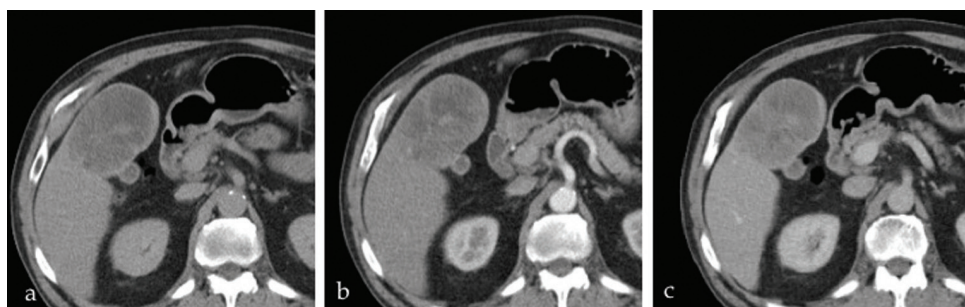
Hepatocellular adenoma on (a) pre, (b) arterial and (c) portal phase computed tomography showing an indeterminate heterogeneous mass with some internal enhancement, subsequently imaged by magnetic resonance imaging.
